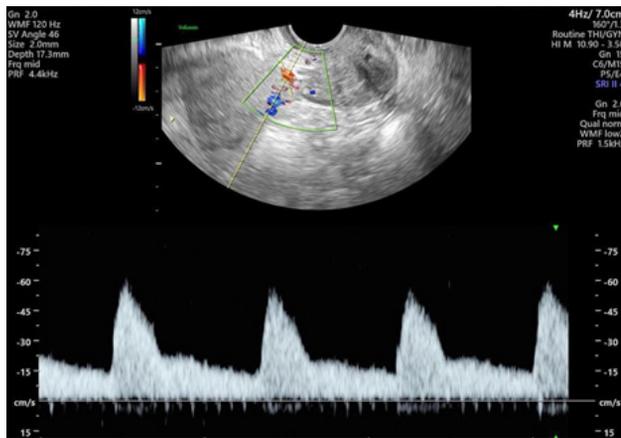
Uterine artery Doppler; a sagittal view of the uterus with color Doppler visualizing the uterine artery at the level of the internal os.
